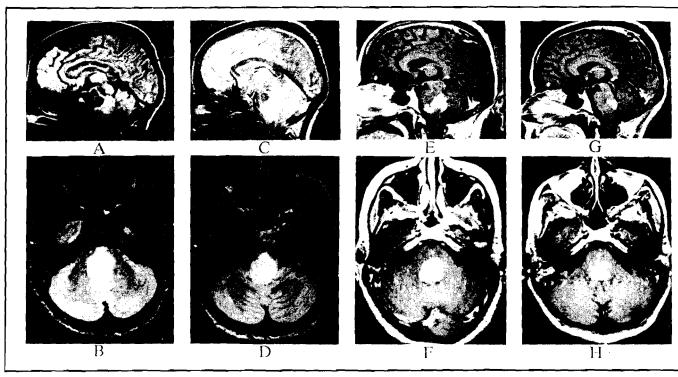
Localization of the brainstem anaplastic astrocytoma by MRI. Sagittal (A, C, E, and G) and axial (B, D, F, and H) views. A through D were proton density images (gadolinium was not yet available), while E through H were T_1 images with gadolinium enhancement. (A and B) Prior to biopsy and therapy. Abnormal signal is present from the upper medulla to the pons, enveloping the 4th ventricle and distal aqueduct. (C and D) Scan 3 months later, at the time of initial development of CNH. Progressive caudal extension of the abnormal signal into the ventral medulla has occurred. (E and F) Gadolinium MRI 10 months after diagnosis, showing enhancement in the ventral rostral medulla, and pontine tegmentum and tectum. (G and H) At 30 months, after chemotherapy and off steroids, showing reduction in enhancing tissue.
